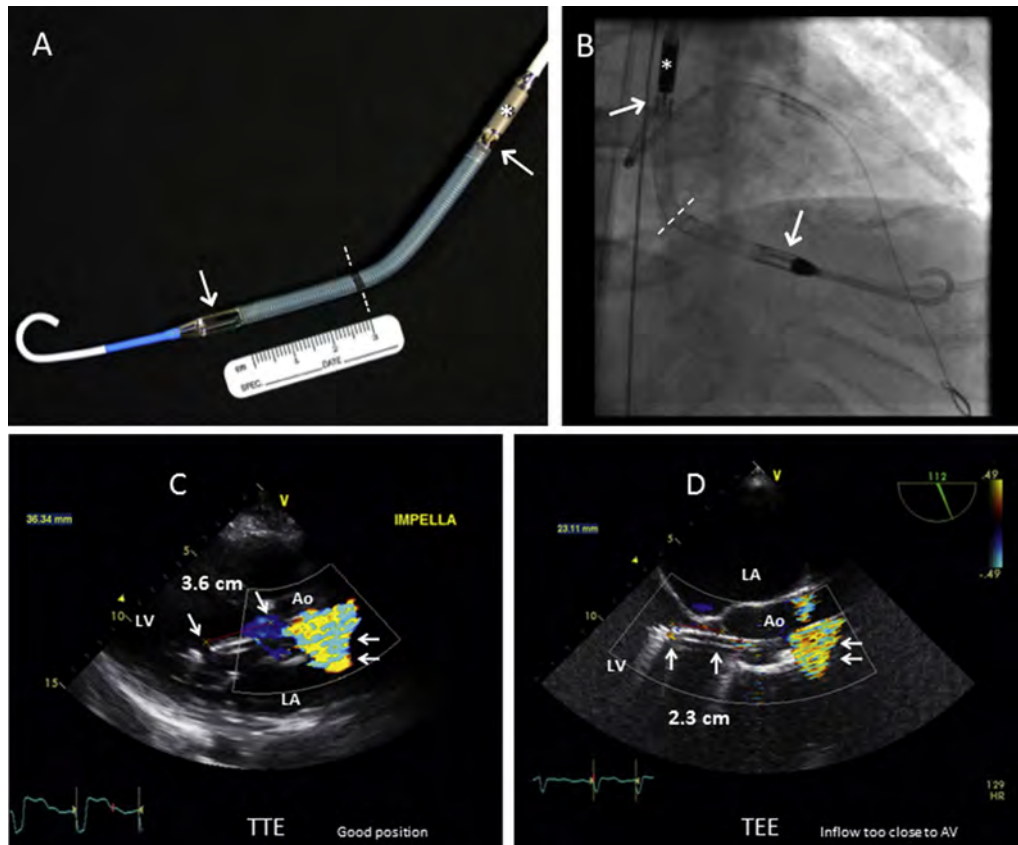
(A) Photograph of the Impella CP Percutaneous LVAD, showing the pump impeller housing (*), blood-inflow zone (downward arrow) and blood-outflow zone (upward arrow) zones, with the distal pigtail catheter component. (B) Fluoroscopic X-ray image of the Impella CP device in situ. Blood-inflow zone (downward arrow), blood-outflow zone (upward arrow), impeller housing (*). The radiopaque marker (immediately below dotted line) indicates the desired aortic annulus level, which is 3.5 cm from the middle of the inflow zone. (C) TTE parasternal long-axis view. The Impella device crosses the AV. The distance from the blood inflow area (left single arrow) to the aortic annulus (right single arrow) is approximately 3.6 cm. (D) On TEE, the distance from the inflow area (left single arrow) to the aortic annulus (right single arrow) is 2.3 cm; this is not far enough into the left ventricle to provide a safety margin, although the device is functioning normally. In views C and D, the double arrows indicate a typical pump-impeller aliased color-Doppler artifact. See also Videos 49 and 50.
